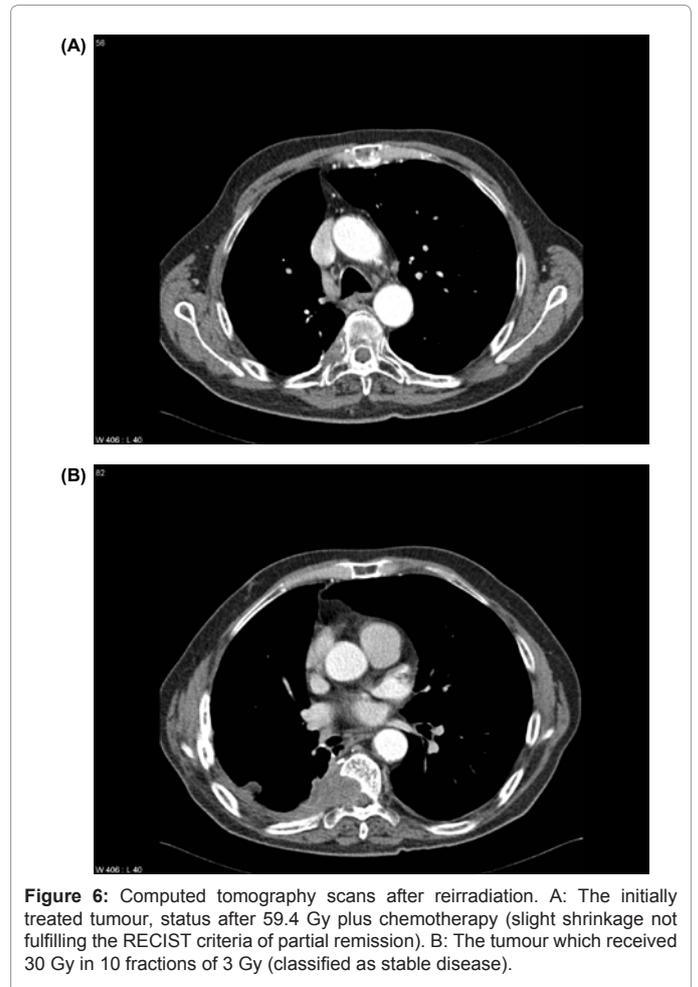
Computed tomography scans after reirradiation. A: The initially treated tumour, status after 59.4 Gy plus chemotherapy (slight shrinkage not fulfilling the RECIST criteria of partial remission). B: The tumour which received 30 Gy in 10 fractions of 3 Gy (classified as stable disease).
